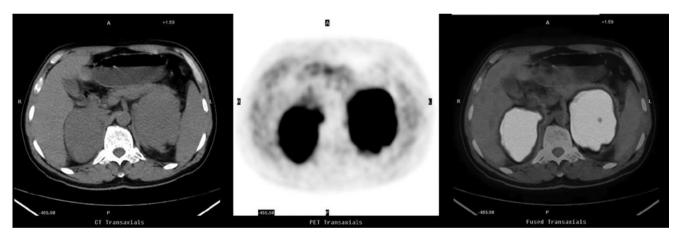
First <sup>18</sup>F-FDG PET/CT scan. High uptake of tracer in the bilateral adrenals with max SUV 19.5 and 29.0, respectively.
